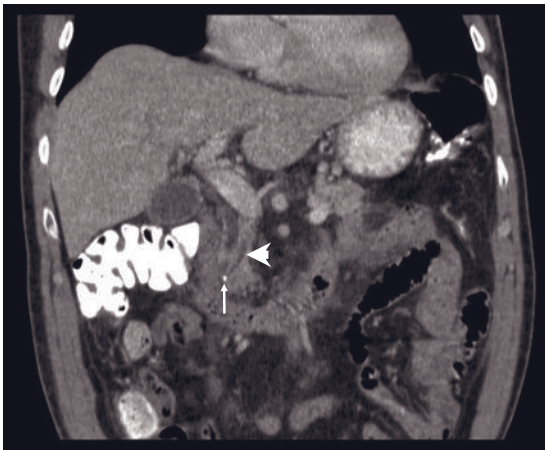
CT showing common bile duct (CBD) stone and pancreatitis. A 3-mm gall stone (arrow) obstructs the CBD at the confluence of the CBD and the main pancreatic duct. The CBD and pancreatic duct (shown here, arrowhead) are dilated. There is moderate peripancreatic edema, consistent with acute pancreatitis. (Courtesy of H Vargas, MD, Divisions of Gastroenterology and Hepatology, and Joseph M Collins, MD, Department of Radiology, Mayo Clinic, AZ.)
